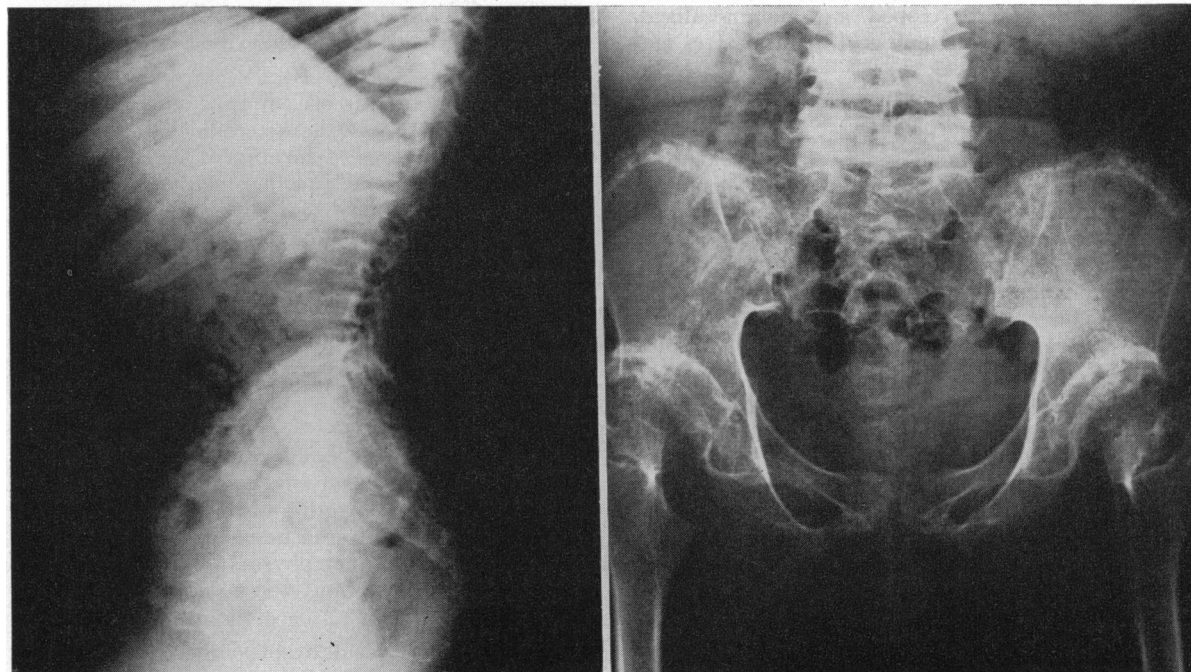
(Patient B).—The roentgenographic changes in the spine, pelvis and long bones are similar to those noted in Patient A, but they are slightly less pronounced. There are somewhat more degenerative changes at the margins of the acetabula. A partial subluxation in both hips is present. The tubular bones are thin and slightly demineralized (atrophy of disuse?). They are not otherwise abnormal.
